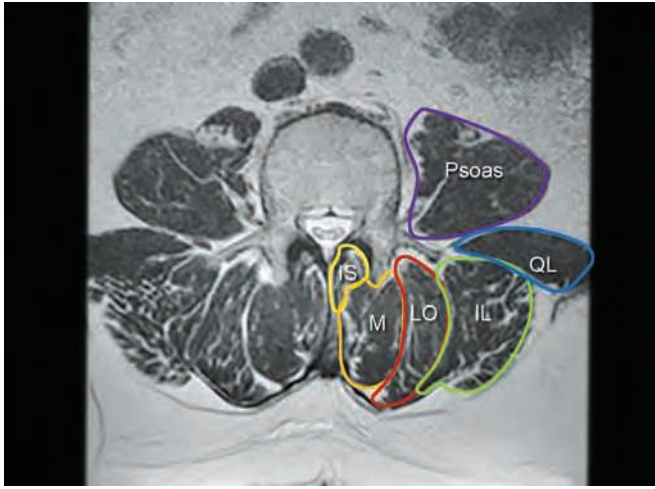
Cross-sectional MRI image on L4 level showing the interspinalis (IS), multifidus (M), longissimus (LO), iliocostalis (IL), quadratus lumborum (QL), and psoas muscles.
